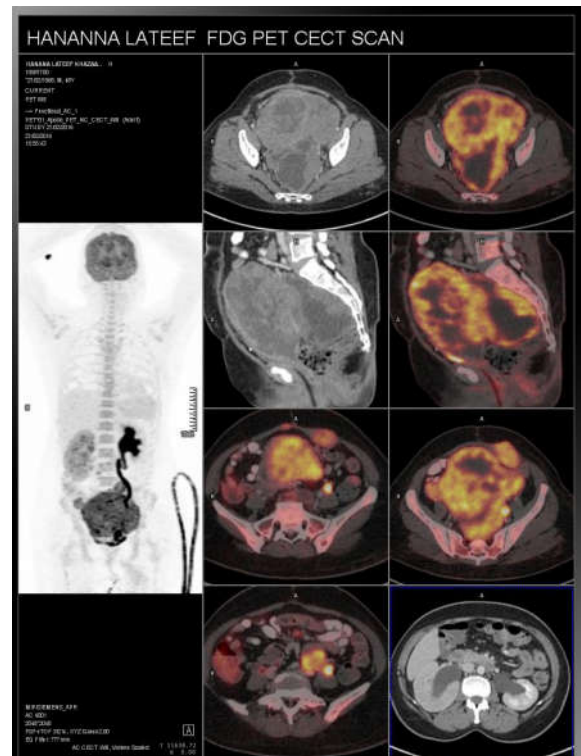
2 & 3 the collage has a MIP image, axial section and sagittal section of the lobulated pelvic mass lesion (both CT and PET CT), axial images of abdominal muscle deposits (PET CT images), axial section of left common iliac node (PET CT) and axial image of bilateral hydronephrosis (CT image)
